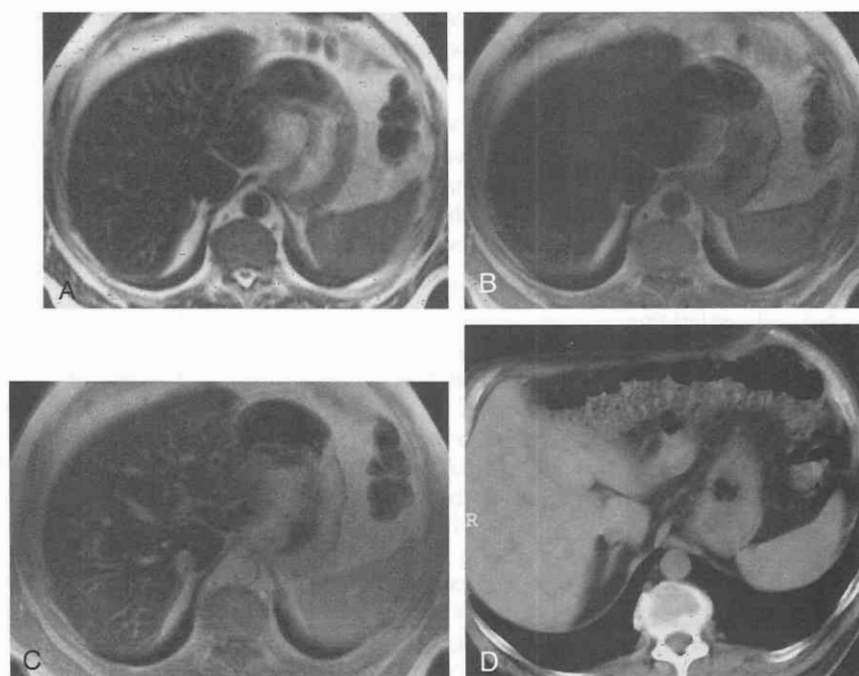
Primary hemochromatosis in a 68-year-old man. In both the T2-weighted image (A) (TSE sequence TR/TE/NSA/ETL/TA 3000/138/1/29/22) and the T1-weighted image (FLASH gradient-echo sequence TR/TE/NSA/FA/TA 84.2/4.1/1/70°/14) before (B) and after (C) application of gadolinium-DTPA (Gd-DTPA), signal intensity is significantly reduced. Unenhanced CT scan (D) shows a normal liver with attenuation of the hepatic parenchyma at 61 HU.
